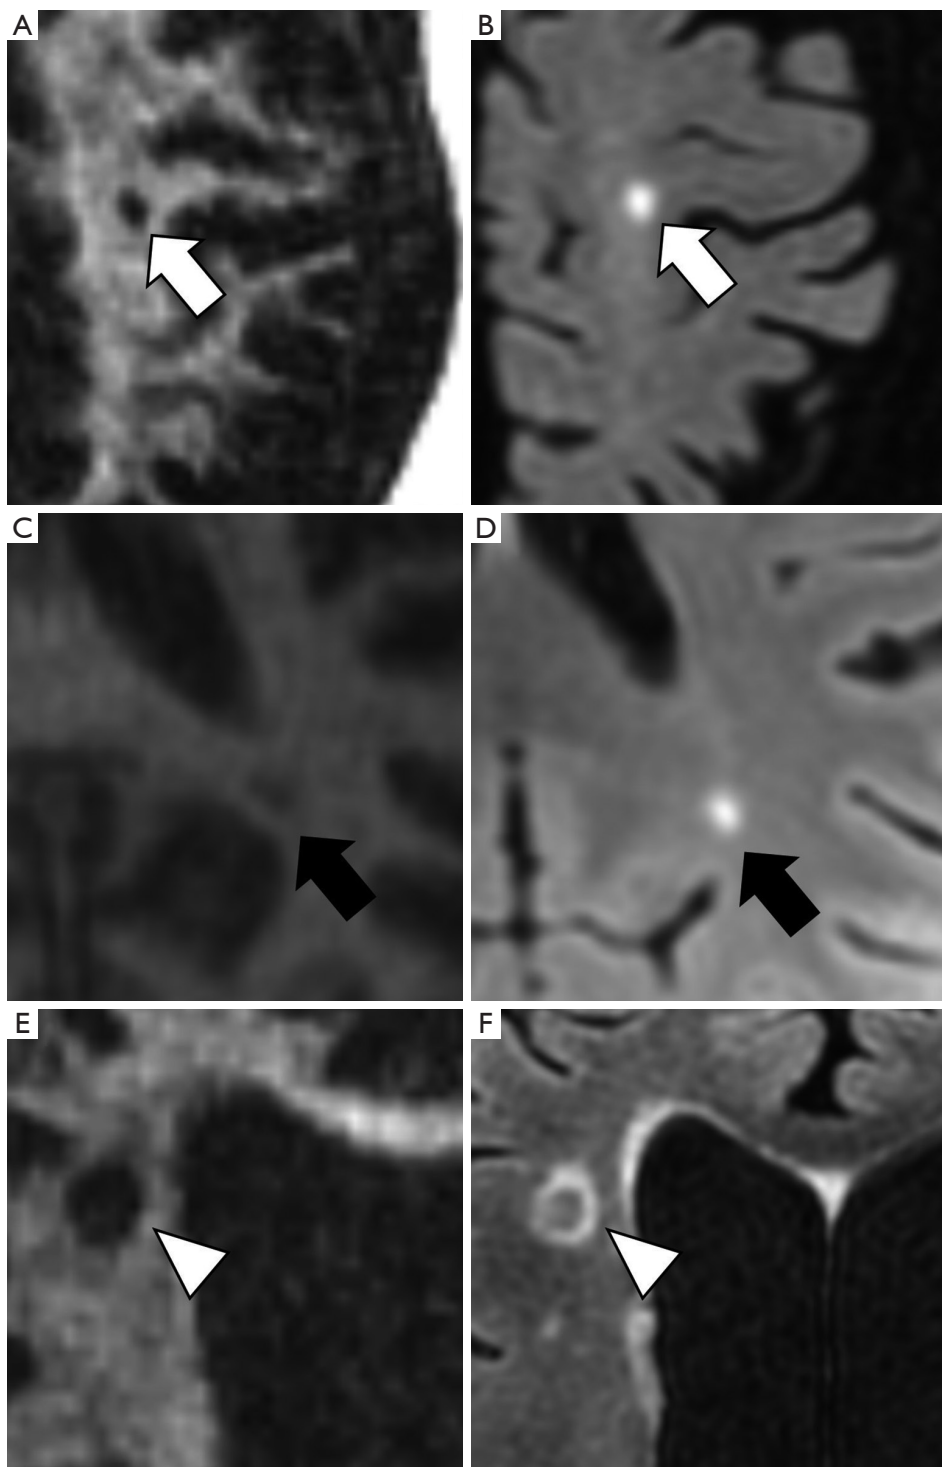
Examples of WML on 3D IR-UTE (A,C,E) and 3D FLAIR (B,D,F). (A,B) Show a lesion near the GM that is clearly to distinguish on both sequences (white arrow), while images (C,D) present a small lesion near the GM of under 2 mm (black arrow), which is not sufficient to detect on 3D IR-UTE. (E,F) Show a clearly identifiable periventricular WML (white arrowhead). WML, white matter lesion; IR-UTE, inversion recovery ultrashort echo time; FLAIR, fluid-attenuated inversion recovery; GM, grey matter.
